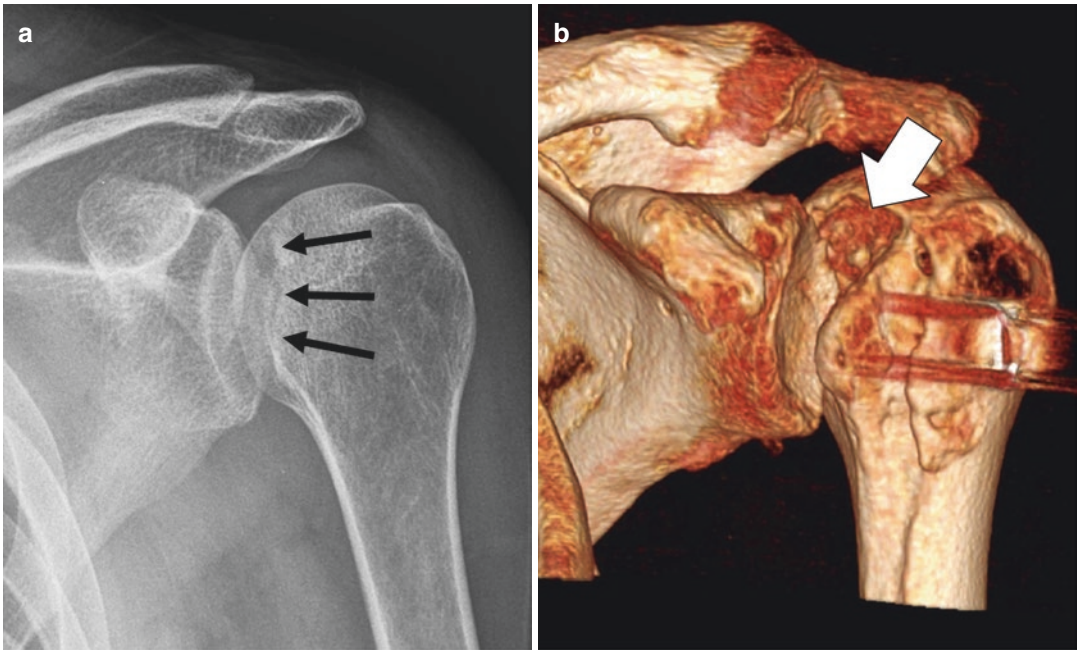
Trough lesions in posterior glenohumeral joint dislocations. (a) This patient shows a posteriorly dislocated humerus with an impaction fracture in the anterior surface of the humeral head manifested as a linear vertically oriented area of sclerosis (arrows). (b) A 3D CT
